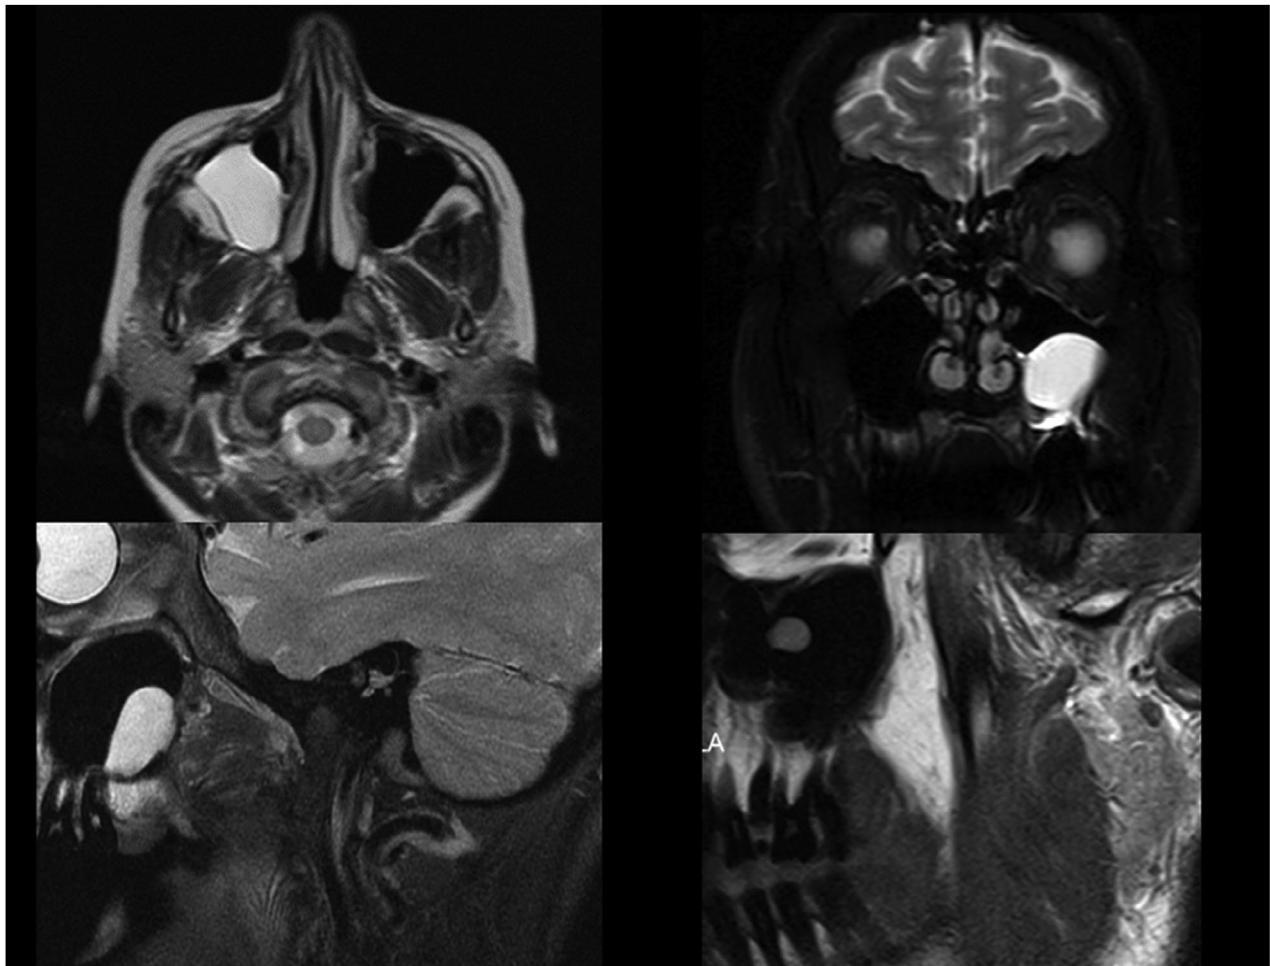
Axial, sagittal and coronal T1 and T2-weighted magnetic resonance (MR) images showing mucous retention cyst of a patient with bilateral temporomandibular joint (TMJ) pain.
